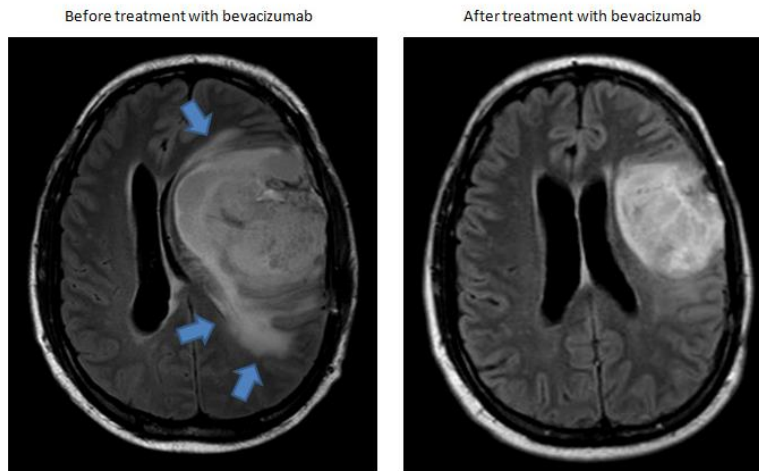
MRI images of recurrent GBM in a 44 y patient. Arrows indicate tumor associated vasogenic edema before bevacizumab treatment. Post treatment, edema significantly decreased showing a clinical benefit.
